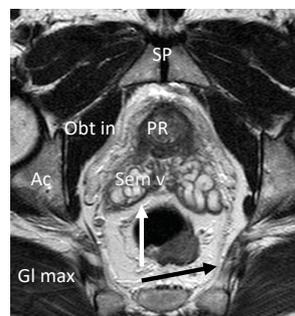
Axial oblique T 2-w MR image taken at the level of the acetabulum (Ac) showing the Denonvilliers fascia (white arrow) as a reinforcement of the hypointense posterior margin of the seminal vesicles (Sem ves). SP= symphysis pubis; Gl max = gluteus maximus muscle; Obt in = obturator internus muscle.
